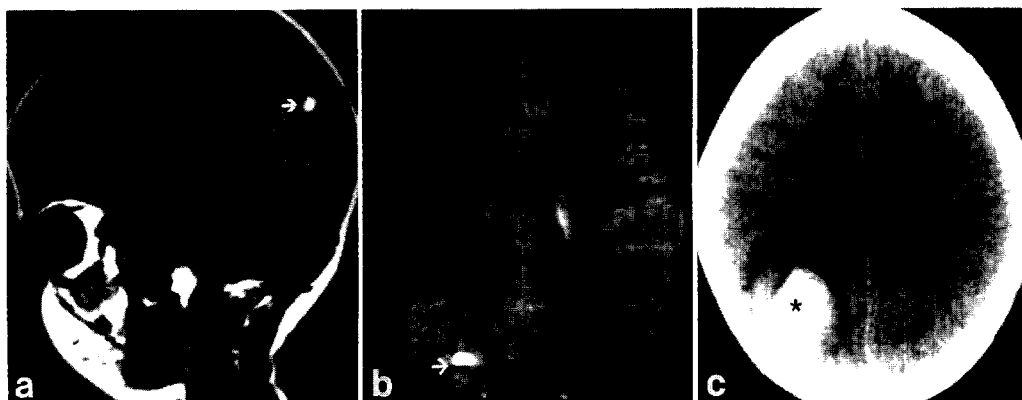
Radiographic studies in Case 17, a 5-year-old boy, the sibling of Case 10. a and b: Screening sagittal T₁-weighted (a) and axial T₂-weighted (b) magnetic resonance images showing a focal right parietal lesion (arrows) with high-intensity (methemoglobin) and low-intensity (hemosiderin) signals. c: Computerized tomography scan 1 year later, following the acute onset of headache and lethargy, demonstrating a high-density hemorrhage (asterisk) with surrounding edema.
